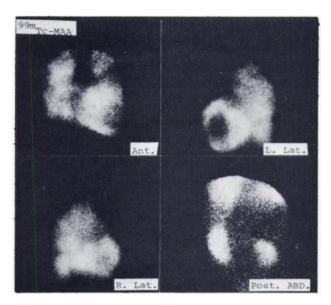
Perfusion lung scintigrams show diffuse heterogeneous uptake. Myocardial activity is clearly evident, most distinctly in anterior and left lateral views. Significant renal activity confirms presence of a right-to-left shunt. Band-like area of pulmonary ischemia in left upper lung field is seen just above myocardial activity in anterior view. This corresponds to radiographic lung density.
